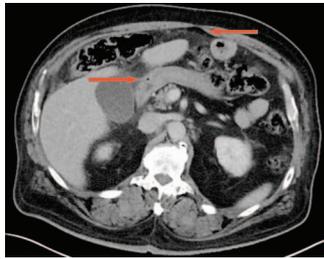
Abdominal CT showing intraperitoneal free fluid with free air and cholelithiasis (arrows).
